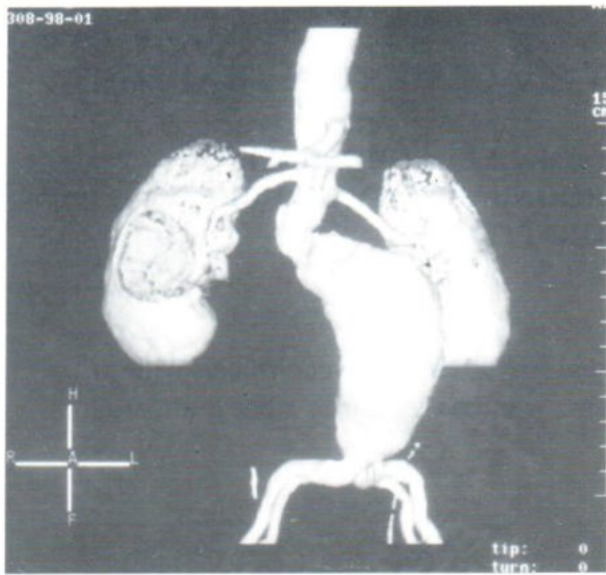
Computed tomography angiogram also showed an infra-renal aortic aneurysm.
